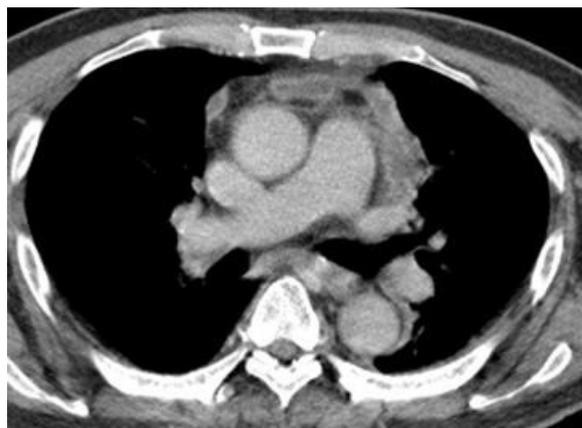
CT axial view of thorax demonstrating complete resolution after 2 months of therapy.
